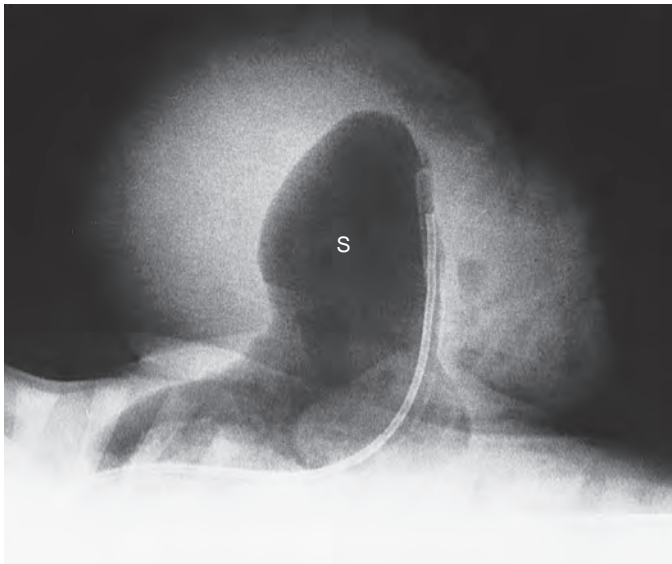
Omphalocele. Lateral abdomen radiograph reveals a membrane-covered omphalocele. The sac of the omphalocele is outlined by air and clearly seen, but individual bowel loops cannot be identified because they are not exposed to air, unlike the situation in gastroschisis. The air-filled stomach (S) protrudes into the omphalocele.
